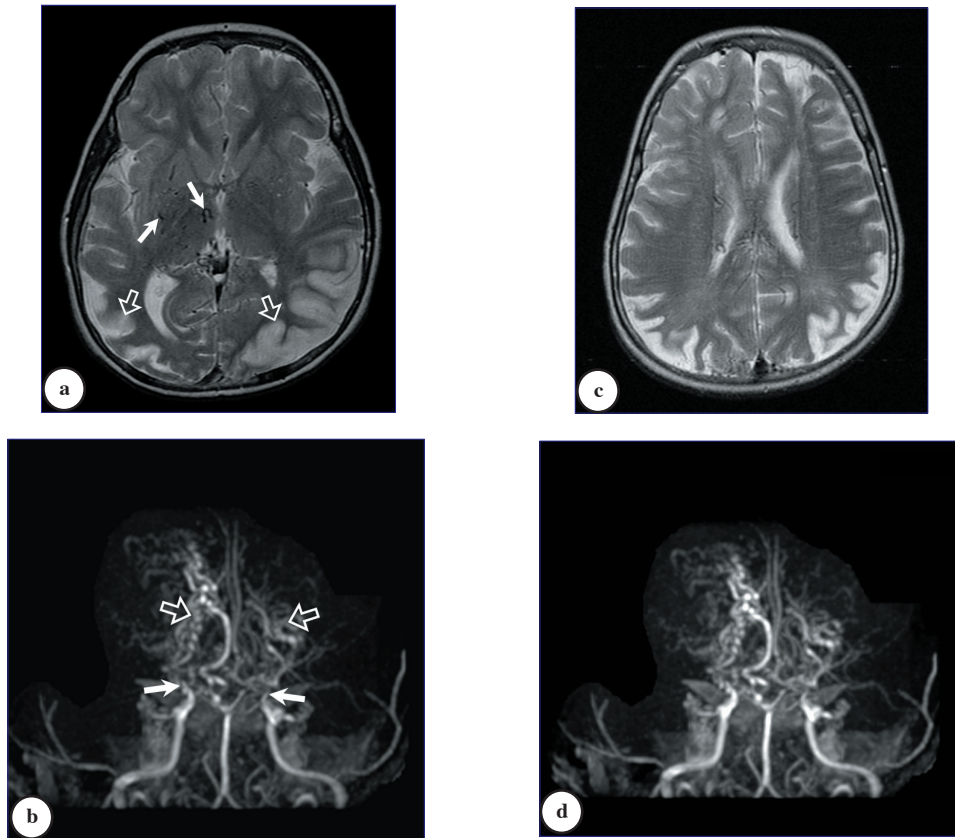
a) Axial T2-weighted (T2W) MR image of the brain showing swelling of the left and right parieto-occipital gyri with increased signal intensity (open arrows) due to recent infarction. Multiple areas of signal voids (arrows) are seen in the region of the basal ganglia representing moyamoya vessels. b) MR angiography showing markedly attenuated caliber of the terminal part of both internal carotid arteries (arrows) in addition to the origin of both middle, both anterior cerebral, and posterior cerebral arteries. There is dilatation of the thalamoperforators and collateral formation (open arrows). c) Eleven week follow-up axial T2W MRI showing significant reduction in the size of the parieto-occipital infarction. d) The follow-up MR angiography shows no interval changes.
